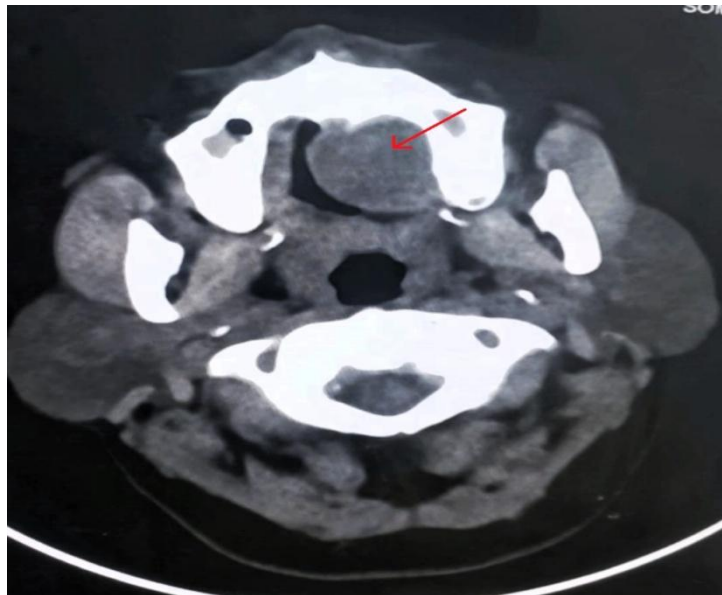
Computed Tomography scan (axial view) showing soft tissue density lesion involving mucosal aspect of left half of the palate (red arrow).
